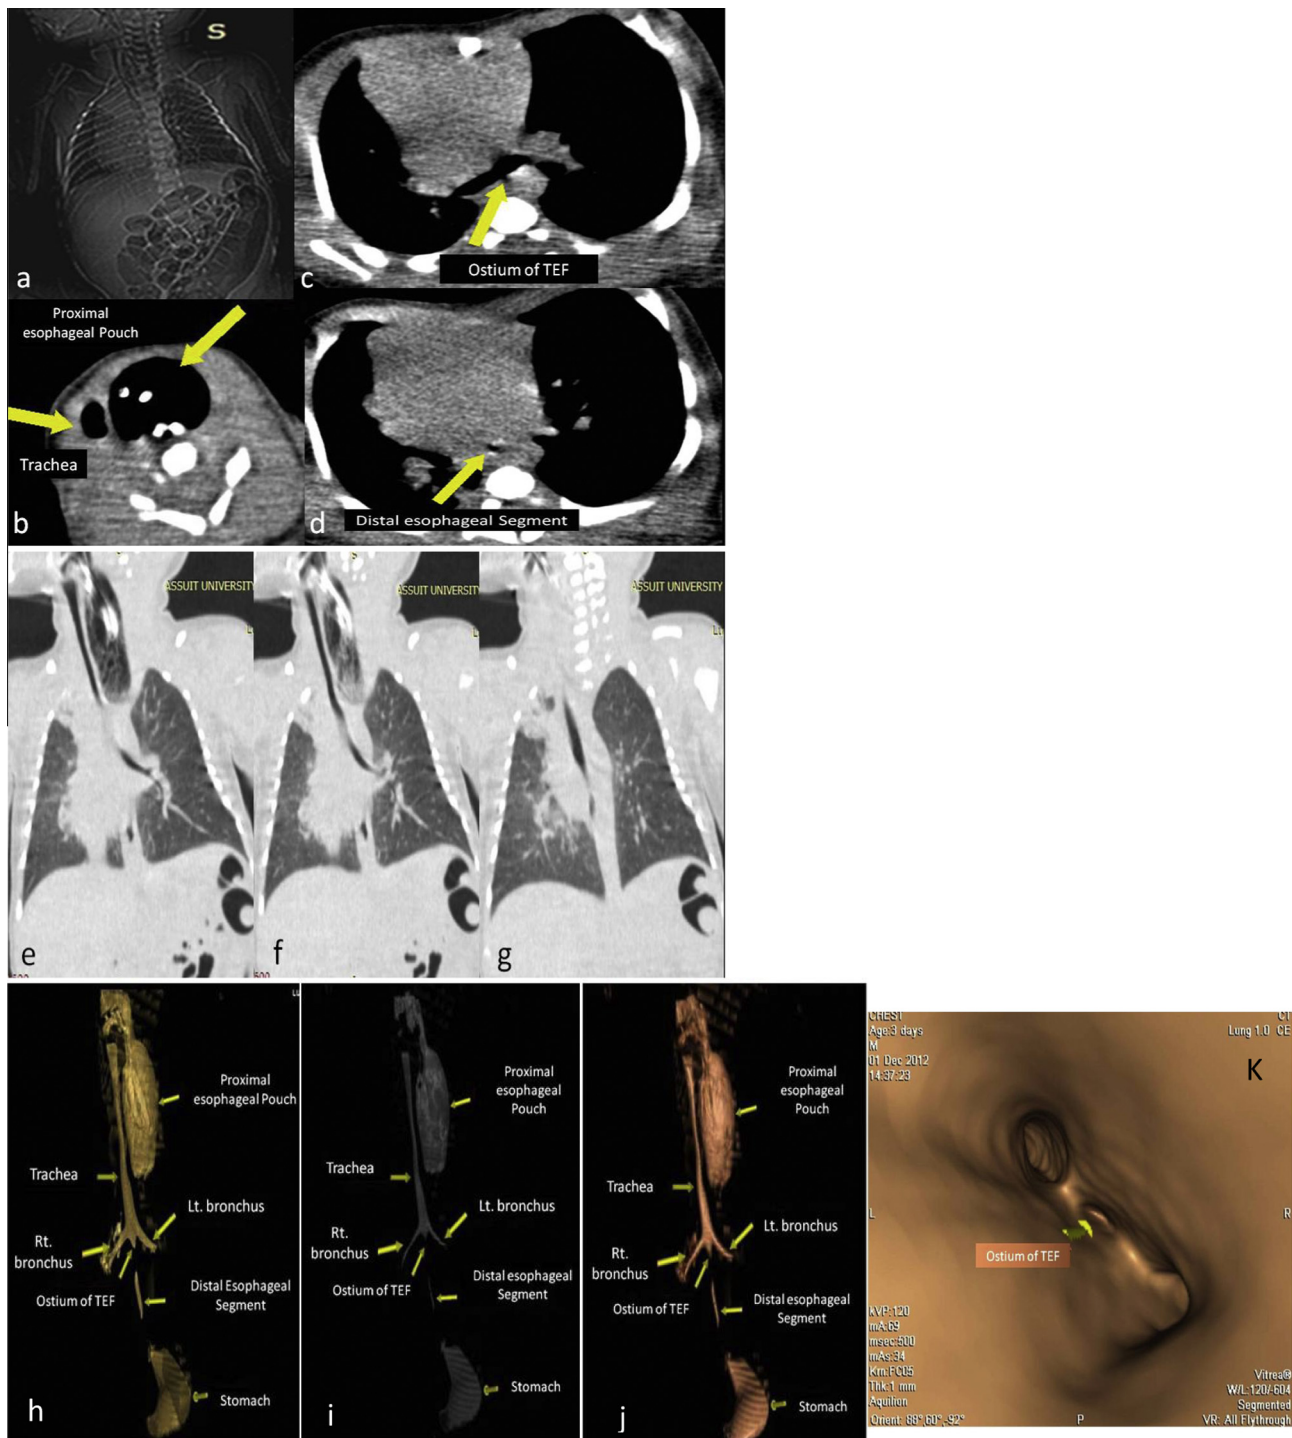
(a) Chest X-ray view revealed proximal esophagus pouch containing kinking nasogastric tube with gas shadows within intestine suggesting type C TEF, (b–d) non-contrast Axial image of TEF, (b) proximal esophagus pouch with kinking nasogastric tube inside it, (c) orifice of TOF connected with the trachea bifurcation and (d) distal esophageal pouch, (e–g) coronal reformatting shows proximal esophagus pouch and distal segment connected with carina, (h–j) 3D TRVR shows proximal esophagus pouch and distal esophagus segment connected with carina, and (k) virtual CT tracheo-bronchoscopy revealed ostium of TEF within the trachea bifurcation (carina).
